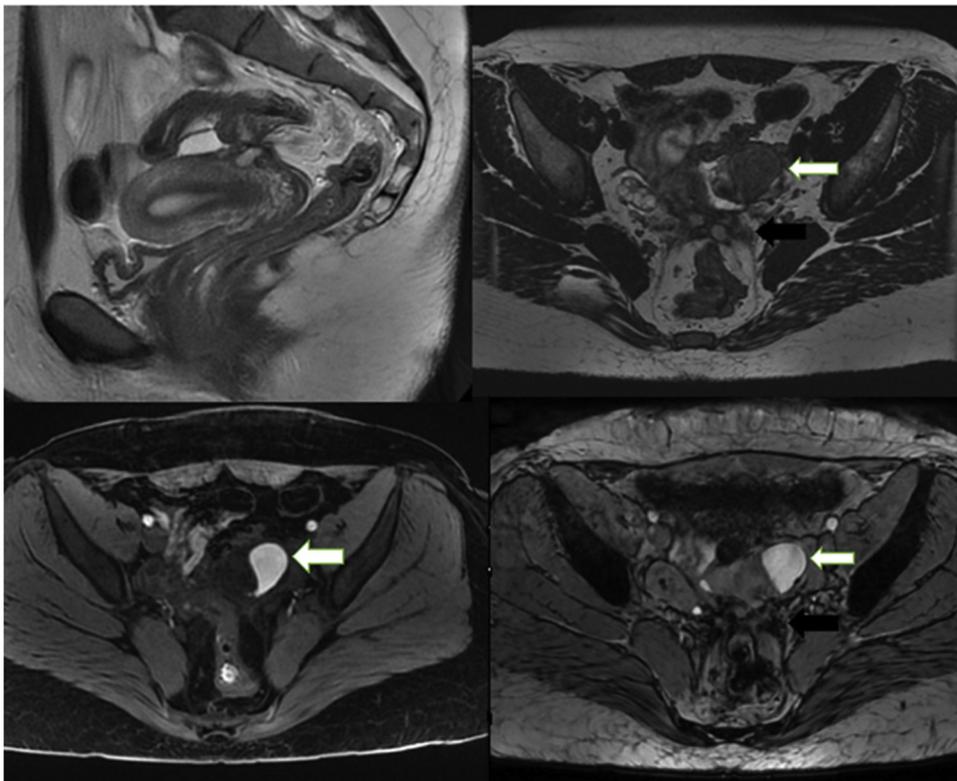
A 28-year-old woman presented fertility disorder. A) Sagittal T2-weighted sequence demonstrates posterior endometriosis of the uterus. B) Axial T2-weighted sequence shows a left cystic mass (white arrow) presenting shading, an involvement of torus uterinus and a thickening of the two USL (black arrow). C) Axial fat saturated T1-weighted sequence demonstrate hyperintense cyst defining an endometrioma, without hyperintense foci of the two USL. D) Axial SWAN sequence reveals the hemorrhagic character of the USL.
